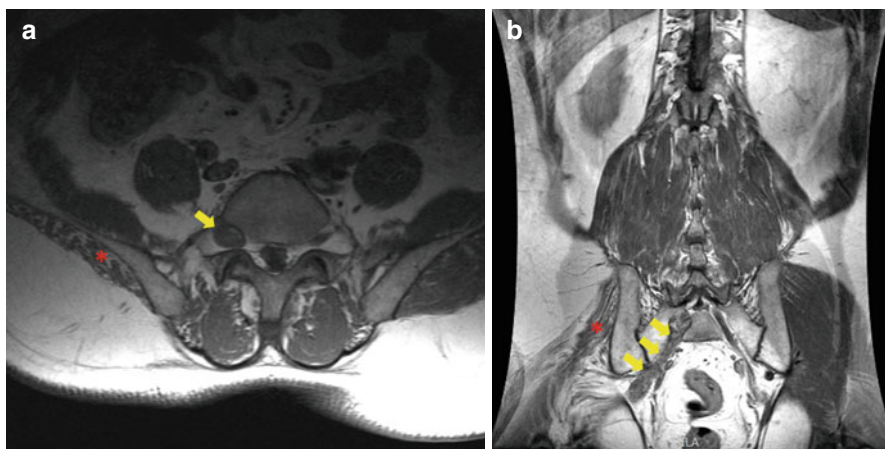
Axial (a) and Coronal (b) T1 weighted magnetic resonance imaging scan showing abnormal signal within the thickened right S1 nerve (yellow arrows) and abnormal signal in the atrophic and denervated gluteal muscles on the right (red asterisk). The normal S1 nerve can be seen on the left for comparison
